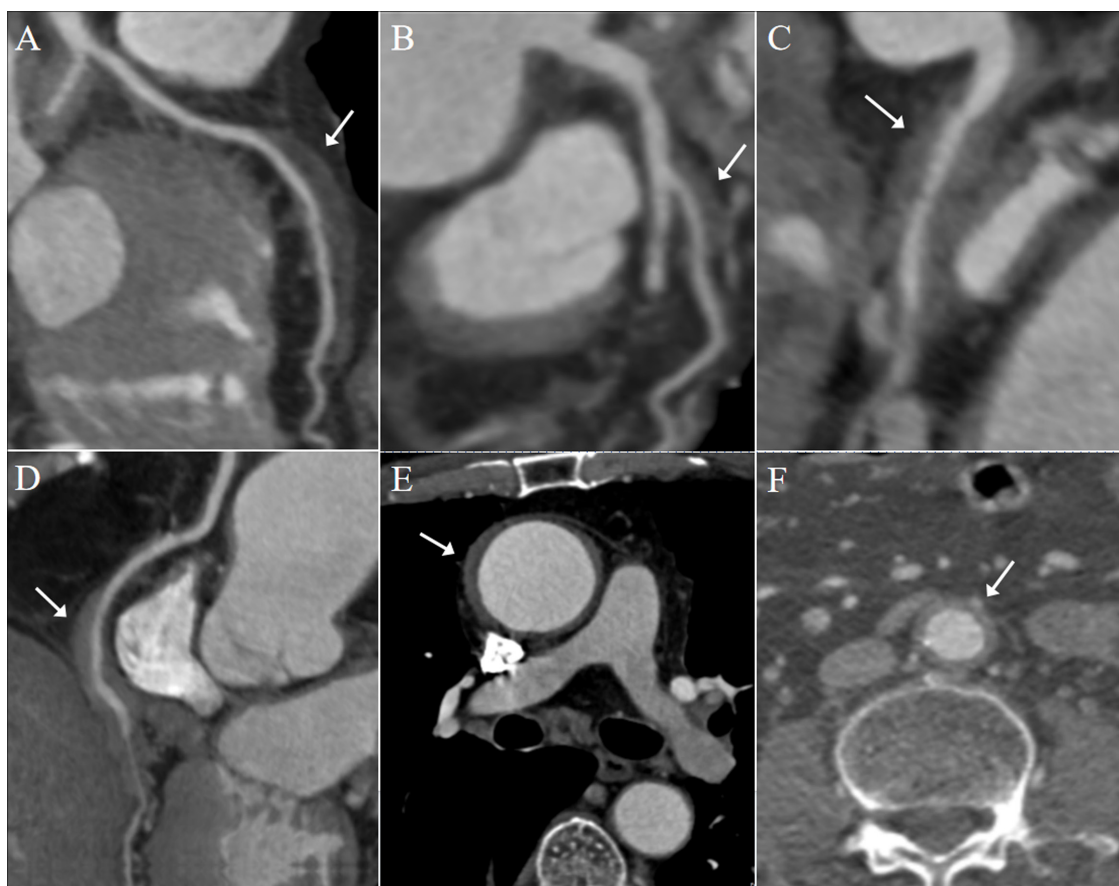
Coronary computed tomography angiography (CTA) revealed a mixed-density, irregular soft tissue mass encasing the mid-segment of the left anterior descending artery (A), left circumflex artery (B, C), and right coronary artery (D). Aortic CTA demonstrated concentric wall thickening of the ascending aorta (E) and abdominal aorta (F), consistent with vascular inflammation.
